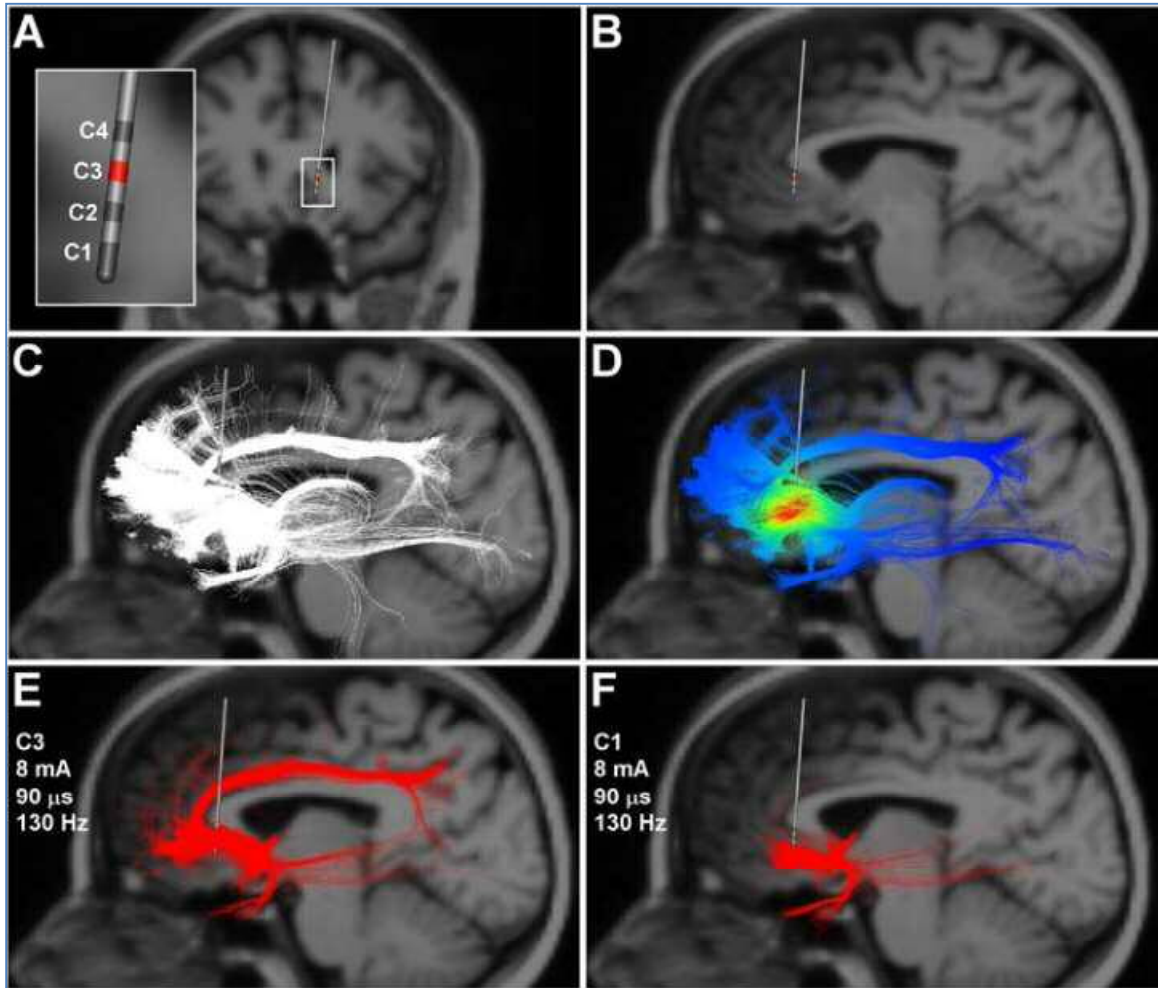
Demonstration of small anatomical location change cause different tract connections. A) Coronal image of the DBS electrode location. Inset shows the St Jude four contact electrodes and the respective contact numbers. Stimulation through contact 3 resulted in the best clinical outcomes. B) Sagittal view of the DBS electrode location. Note that the MRI background image is 3 mm behind the tip of the DBS electrode as not to obscure the tractography results which project in 3D around the electrode. C) White streamlines represent axon model trajectories passing by the DBS electrode. D) Voltage distribution imposed upon each axon model from stimulation at contact 3. E) Axon models (red streamlines) directly activated by therapeutic stimulation. F) Axon models directly activated by non-therapeutic stimulation. (Lujan, Choi, Mayberg et al. (190))
